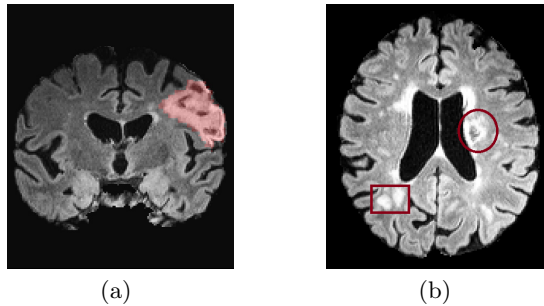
Intensity heterogeneities in stroke lesions at the chronic stage and white matter hyperintensities in FLAIR. (a) Heterogenous intensities inside chronic stage stroke lesion due to CSF filling. The light red mask denotes the entire stroke area as marked by an expert, (b) anomalous FLAIR hyperintensities. The circular region in the image depicts a stroke region while the square area contains other white matter hyperintensities.
